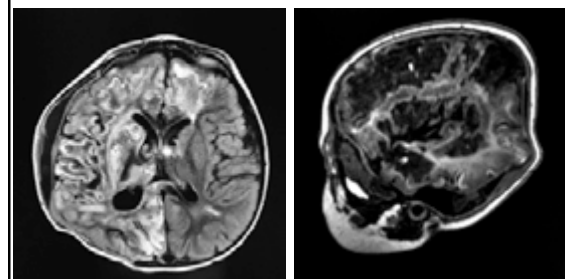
Clinical example Tyler: contrast-enhanced T2 and T1 images acquired in mid-November, showing prominent meningeal inflammation. A: CE T2 FLAIR. B: CE T1. C: CE T1-FSPGR.
